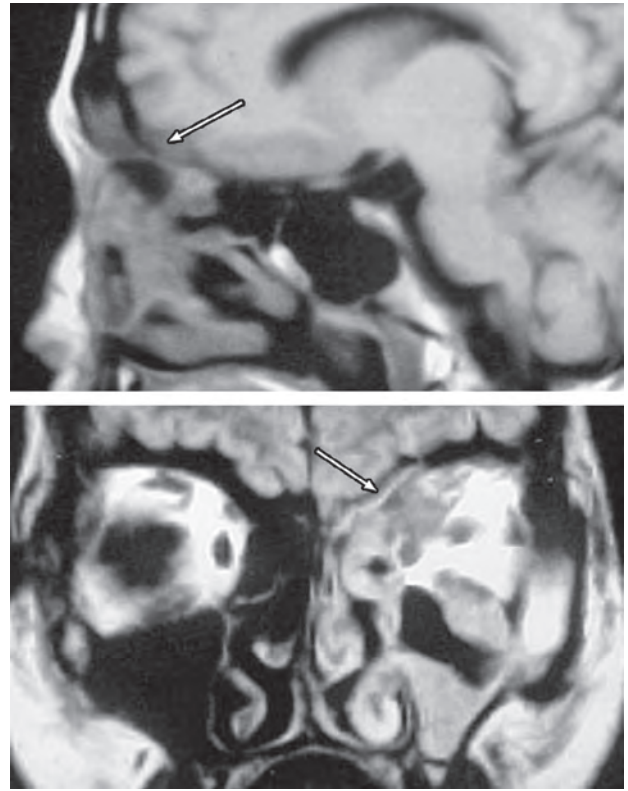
MRI of the brain showing evidence of infection in the ethmoidal sinuses with skull base erosion and spread to the dura seen as dural thickening (arrow) (Stage IIIA)
